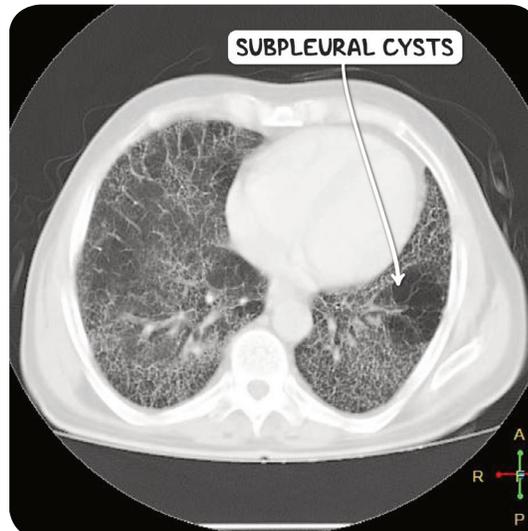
A CT scan of the chest in the axial plane demonstrating marked honeycombing of the lung and a collection of subpleural cysts in an individual with idiopathic pulmonary fibrosis.
